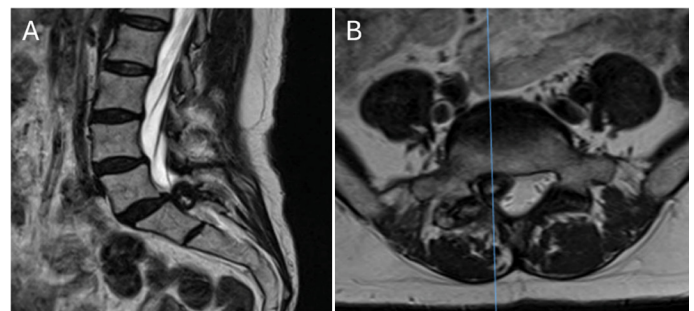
Magnetic resonance imaging in sagittal (A) and axial (B) cuts showed an increase in the lesion in the interapophyseal joint of L5/S1, which promoted significant compression of the dural bag and contact with the descending root of S1.
